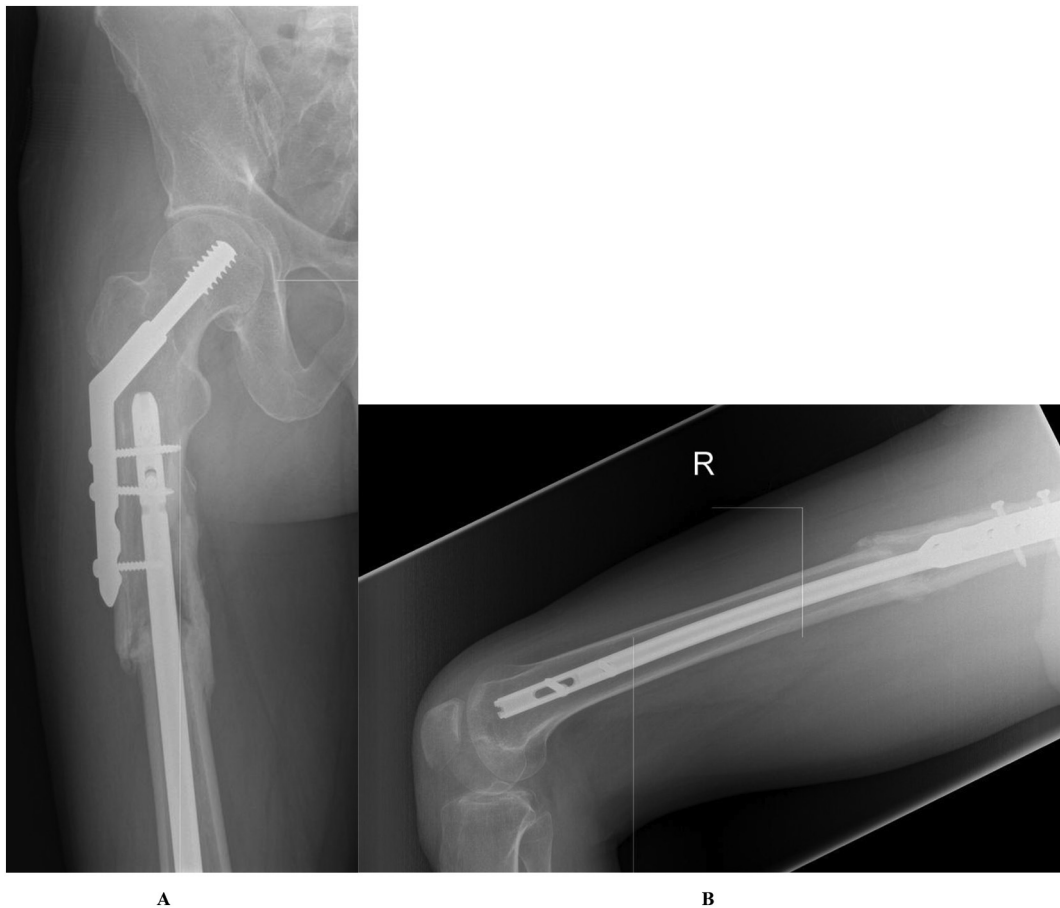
A and B: Anteroposterior (A) and lateral radiographs (B) showing complete healing of the fractures without failure of implants.
